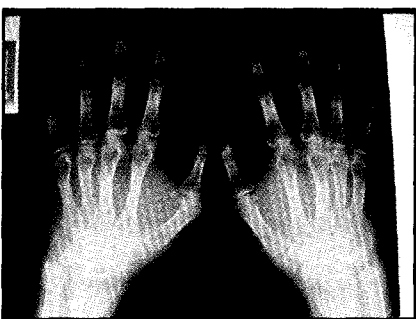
X-rays of the hands in Rheumatoid arthritis. Demonstrates periarticular porosis, joint space narrowing of the proximal interphalangeal joints, and erosions. Note erosion of the ulnar styloid, and narrowing of the wrists. (See Fig 5)
